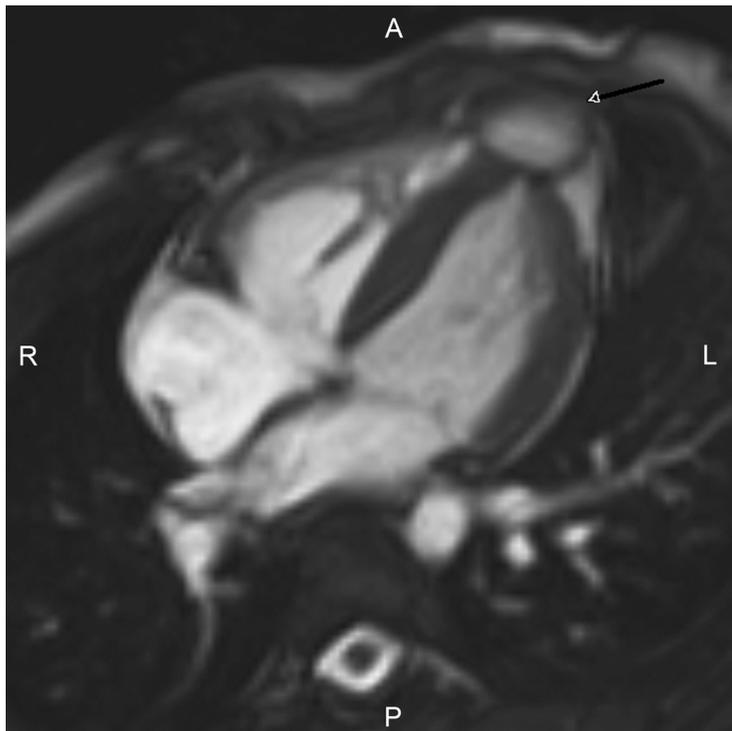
Cardiac MRI demonstrating the right ventricular aneurysm. Arrow denotes right ventricular aneurysm at right ventricular apex.
